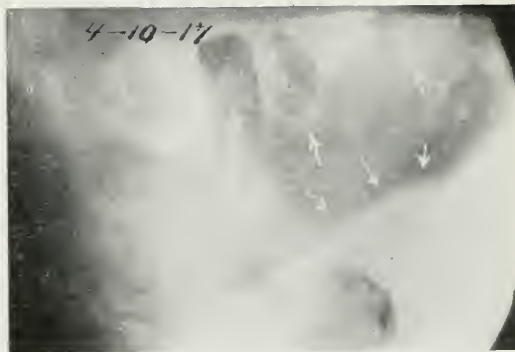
RECURRENT METASTATIC DISEASE OF THE JAW BONE, SHOWING ROENTGENOGRAM OF THE DISEASED AREA AND THE PHOTOGRAPHS SHOWING THE PROJECTION FROM THE JAW BONE BY THE TUMOR MASS AND THE RESULT AFTER RESECTION AND ROENTGEN RAY TREATMENT.
